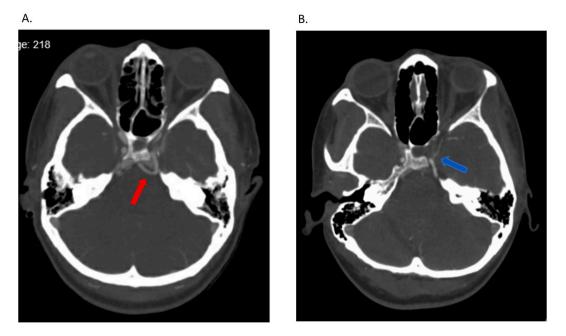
Computed tomography angiogram of head and neck. A. Axial view shows a left persistent trigeminal artery (red arrow). B. Axial view of the left persistent trigeminal artery supplying blood to its ipsilateral medial cerebral artery (blue arrow).
